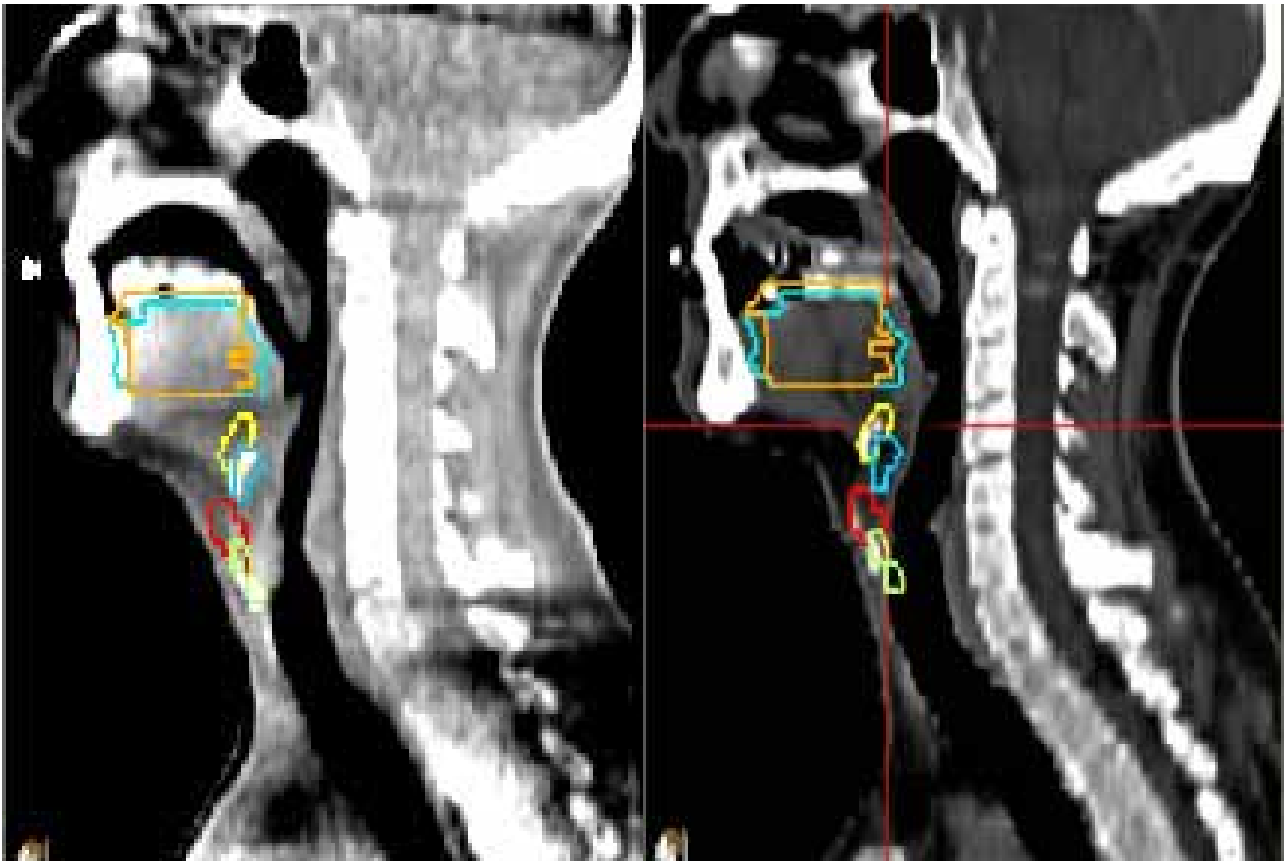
example of planning CT and CBCT with all four anatomical structures independently contoured on each and then fused together.
